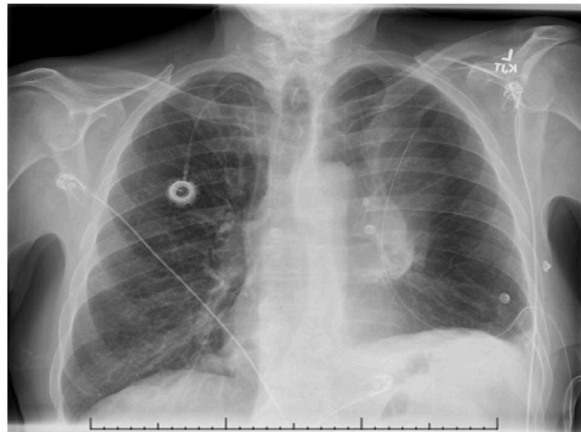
Chest radiograph after one week showing volume loss on the left side.
